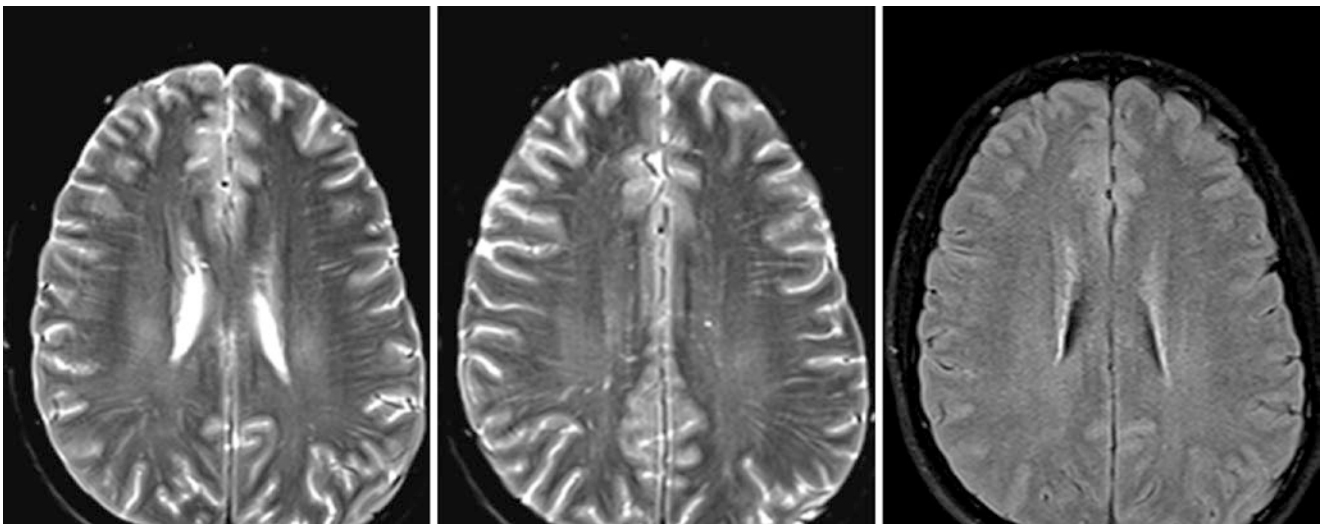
A 23 year old had extensive radiating hyperintensities throughout the deep white matter of the supraventricular white matter on 3T MRI T2WI (*left and middle*), which suppress on FLAIR (*right*).
